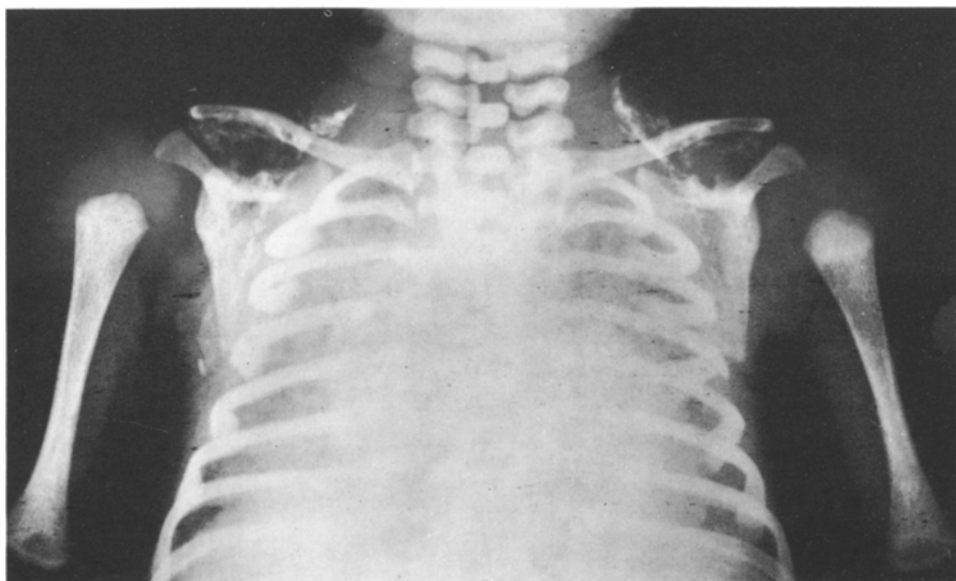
Chest radiograph showing symmetrical triangular areas of calcification within the subcutaneous fat of the supraclavicular fossae. $\times 0.5$
